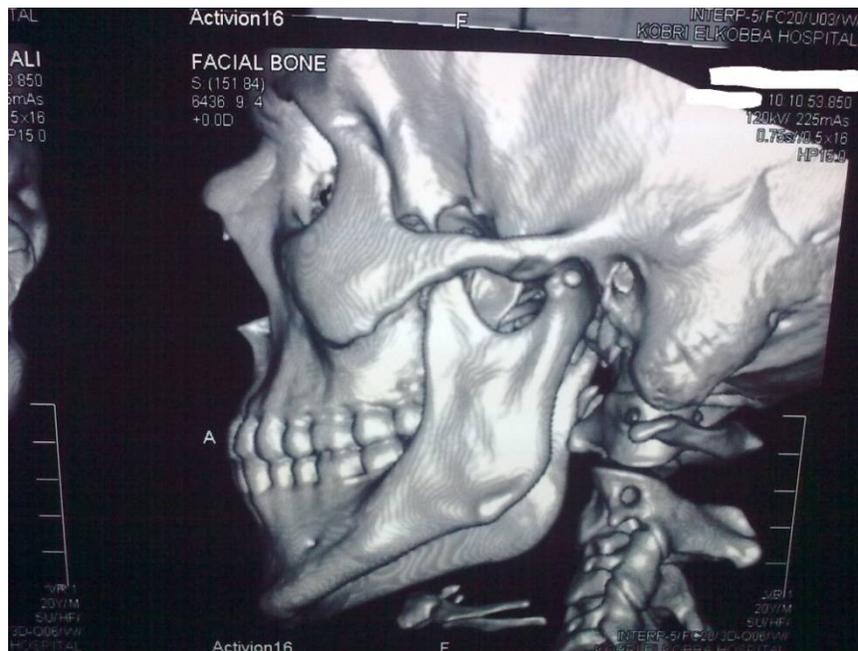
Postoperative CT 3D image.
